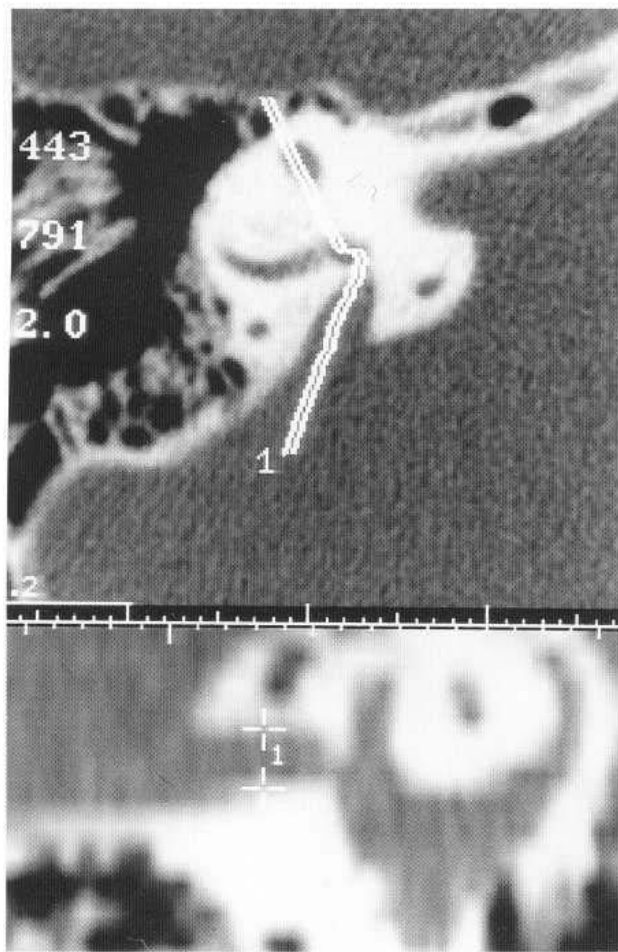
An axial CT section showing a large vestibular aqueduct with a line depicting the plane of reformatting, enabling a measurement to be made in the midportion of the descending limb (labelled 1 and measuring 2.0 mm in diameter).
